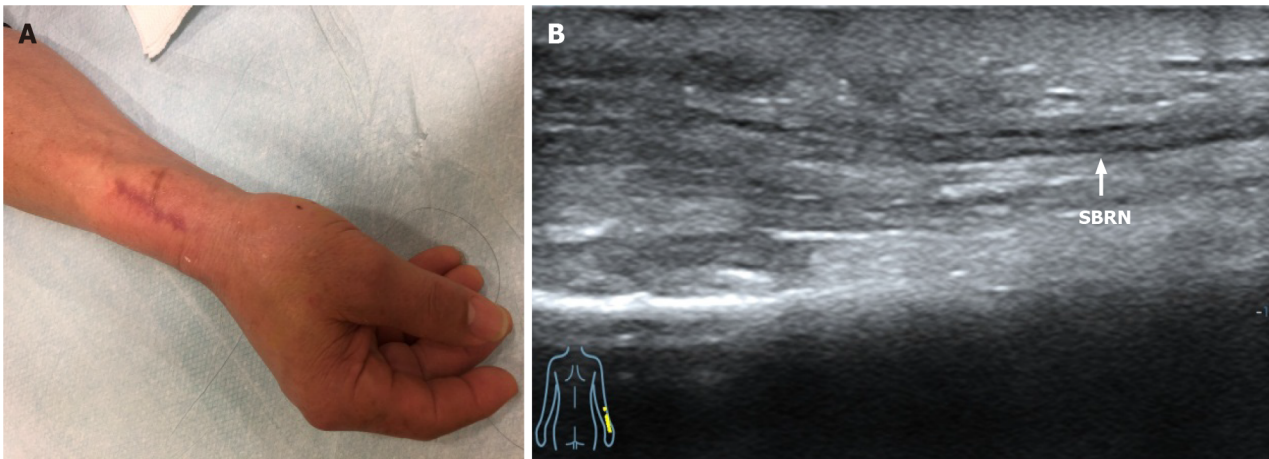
Three months after resection of traumatic neuroma. A: Appearance; B: Ultrasound image shows the long-axis view of the superficial branch of radial nerve adhered to the surrounding tissues (white line). SBRN: Superficial branch of radial nerve.
